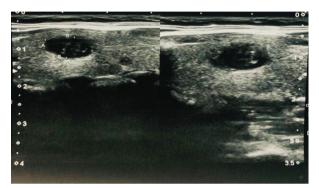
Ultrasonographic picture of right thyroid gland
